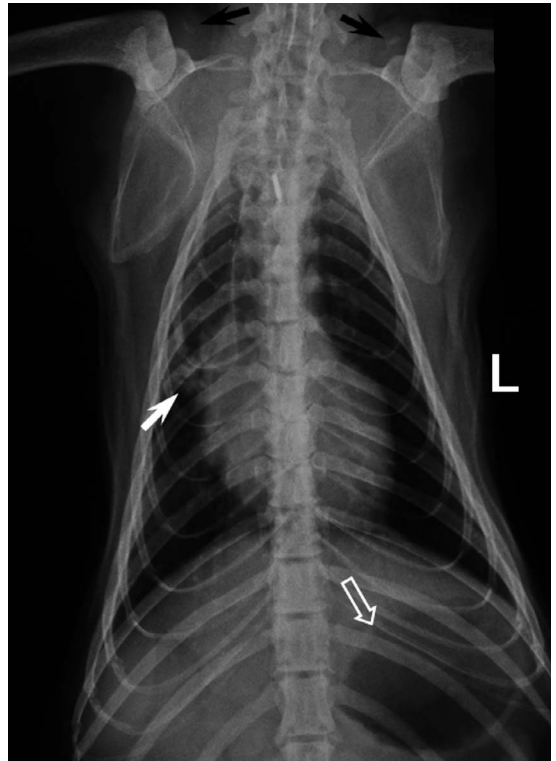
Dorsoventral thoracic radiograph of an 8-yr-old (6-kg) male red panda. The cardiac silhouette is rounded and there is extensive cardiodiaphragmatic contact. Note the presence of a mild alveolar lung pattern (white arrow) in the right hemithorax adjacent to the right cardiac margin as a result of gravity-dependent atelectasis. Note also the presence of gas in the gastric fundus (open white arrow). The clavicles are indicated by black arrows. L = left.
